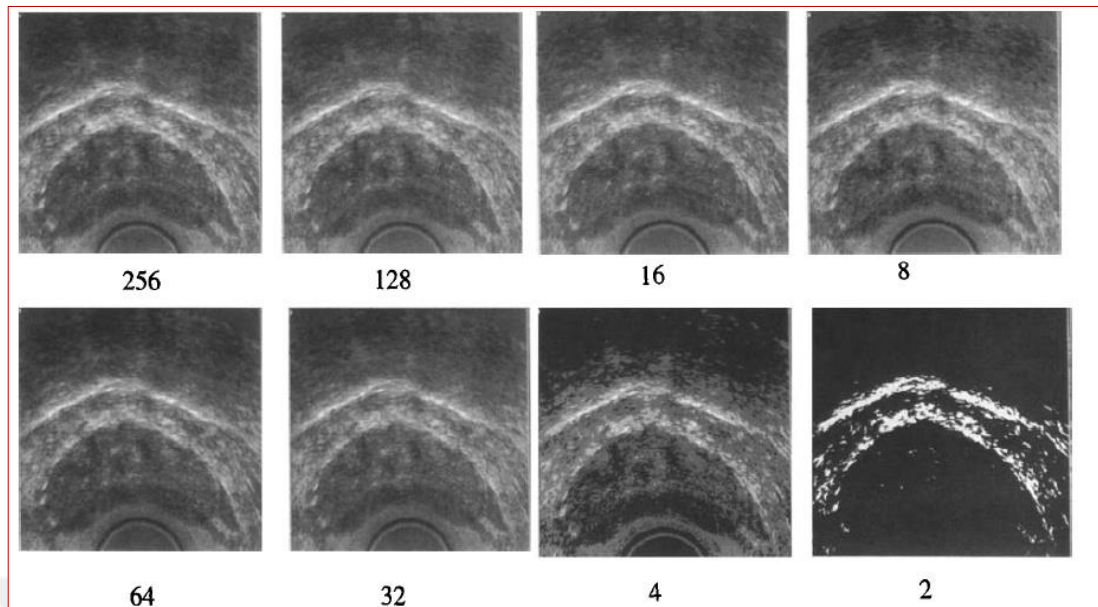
Ultrasound pictures of prostate at exclusive grey ranges. unique image with 265 grey values turned into used to get photos with reduced wide variety of gray (Aarnink et al., 1998)
